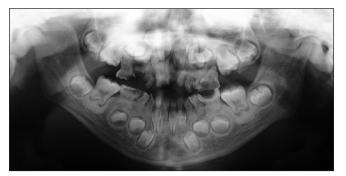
Panoramic radiographs taken at 8 years and 1 month of age.
